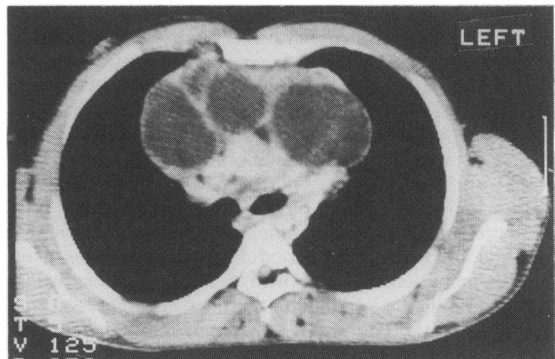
Thoracic computed tomography scan (2.5 cm below the manubriosternal joint) showing areas of tumour and several translucent cystic areas.
